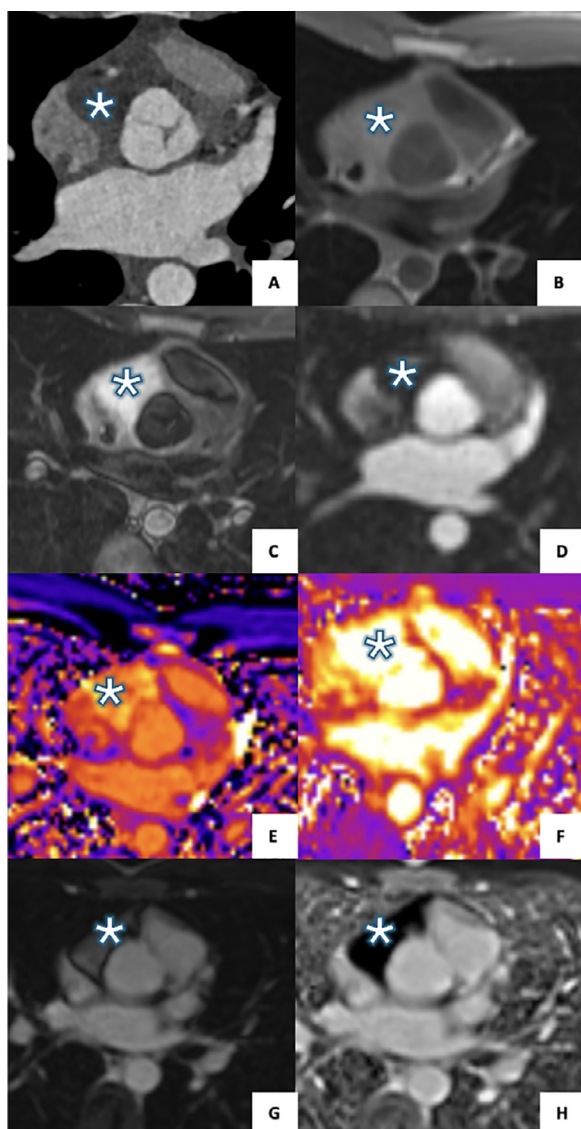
Multimodality mass (*) characterization. CT revealed a mass molding the right atrium, with right paracardiac extension, within which the coronary artery path was identified (A). Cardiac MRI showed: isointense mass on T1 spin echo with encasement of the superior vena cava without compression (B); hyperintense signal on T2 STIR, suggesting a watery or liquid content (C); non-vascularized mass on resting perfusion (D); hyperintense signal on T1 (E) and T2 mapping (F), suggestive of edema or a liquid content (F); possible liquid content on magnitude-only inversion recovery (MAG) LGE (G) and confirmed liquid content on phase-sensitive inversion recovery reconstruction (PSIR) LGE (H).
